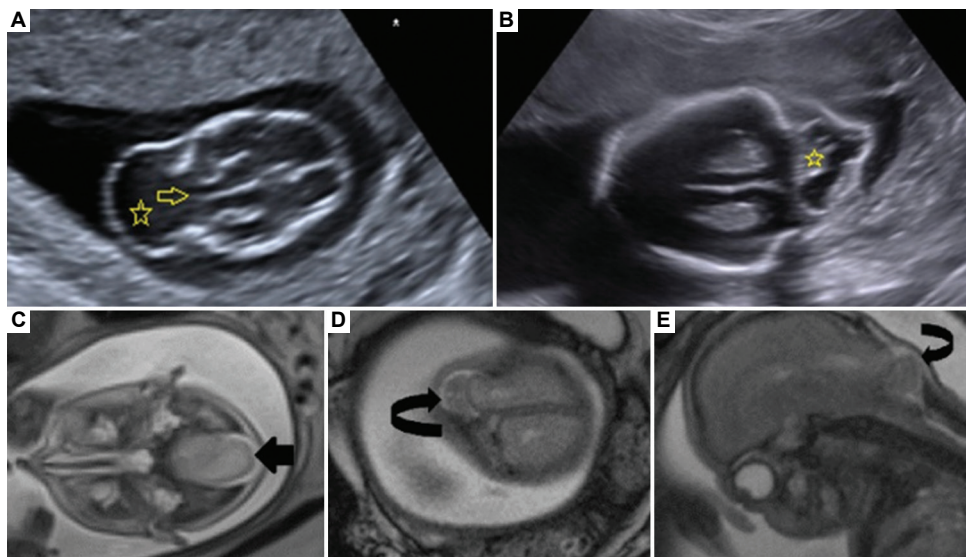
Ultrasound and MRI images of different patients. (A) Axial ultrasound image obtained in the first trimester demonstrates an occipital bone defect (yellow outlined arrow) with an accompanying encephalocele sac (yellow outlined star). (B) The encephalocele sac contains malformed brain structures (yellow outlined star). (C) Axial HASTE, (D) axial TRUFI and (E) sagittal TRUFI images show an occipital encephalocele (black arrow) with an occipital bone defect. The sac includes brain tissue (black curved arrow).
